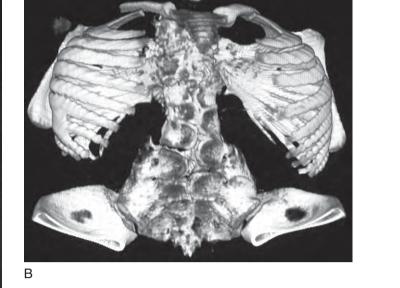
Jarcho-Levin syndrome on PA view (A) and on chest CT scan reconstruction (B) demonstrating the shortened thorax and "fan-shaped" orientation of the ribs relative to the spine. (Courtesy of Dr. Randall Betz.)
